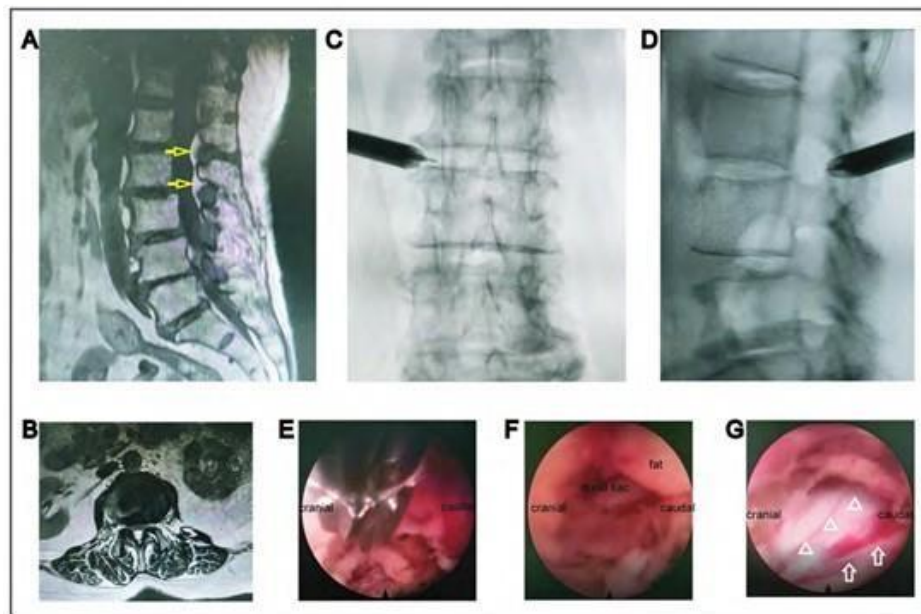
The preoperative imaging data of the patient. Preoperative (A) sagittal magnetic resonance imaging (MRI) image showed epidural fat increase (yellow arrow); preoperative (B) and axial MRI image at the L2–L3 level.
